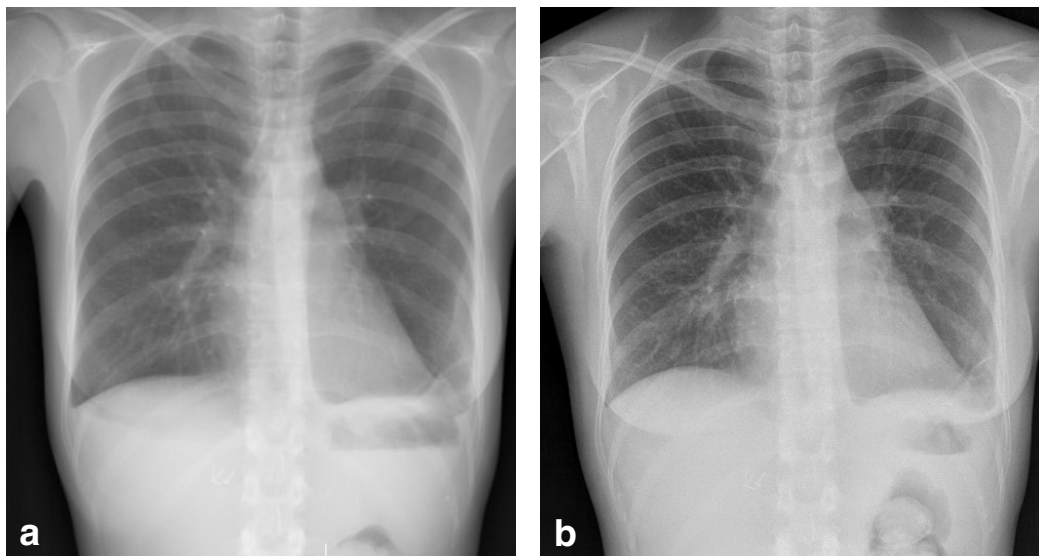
Complete resolution of left-sided CPE is depicted on chest x-ray at a) three months and b) three years after FXIII administration.
